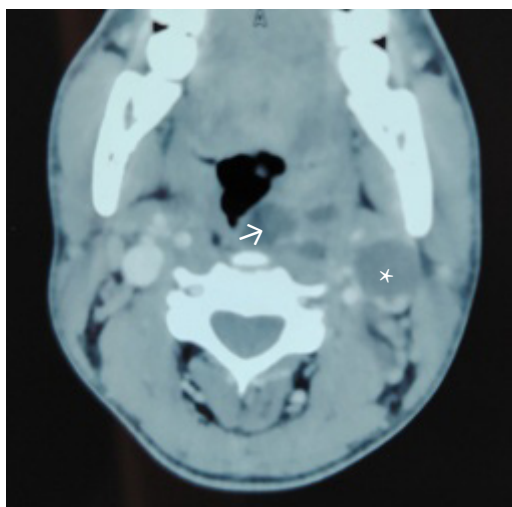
CT scan images showing abscess in A. Retropharyngeal (white arrow) and parapharyngeal space (denoted by star symbol).
